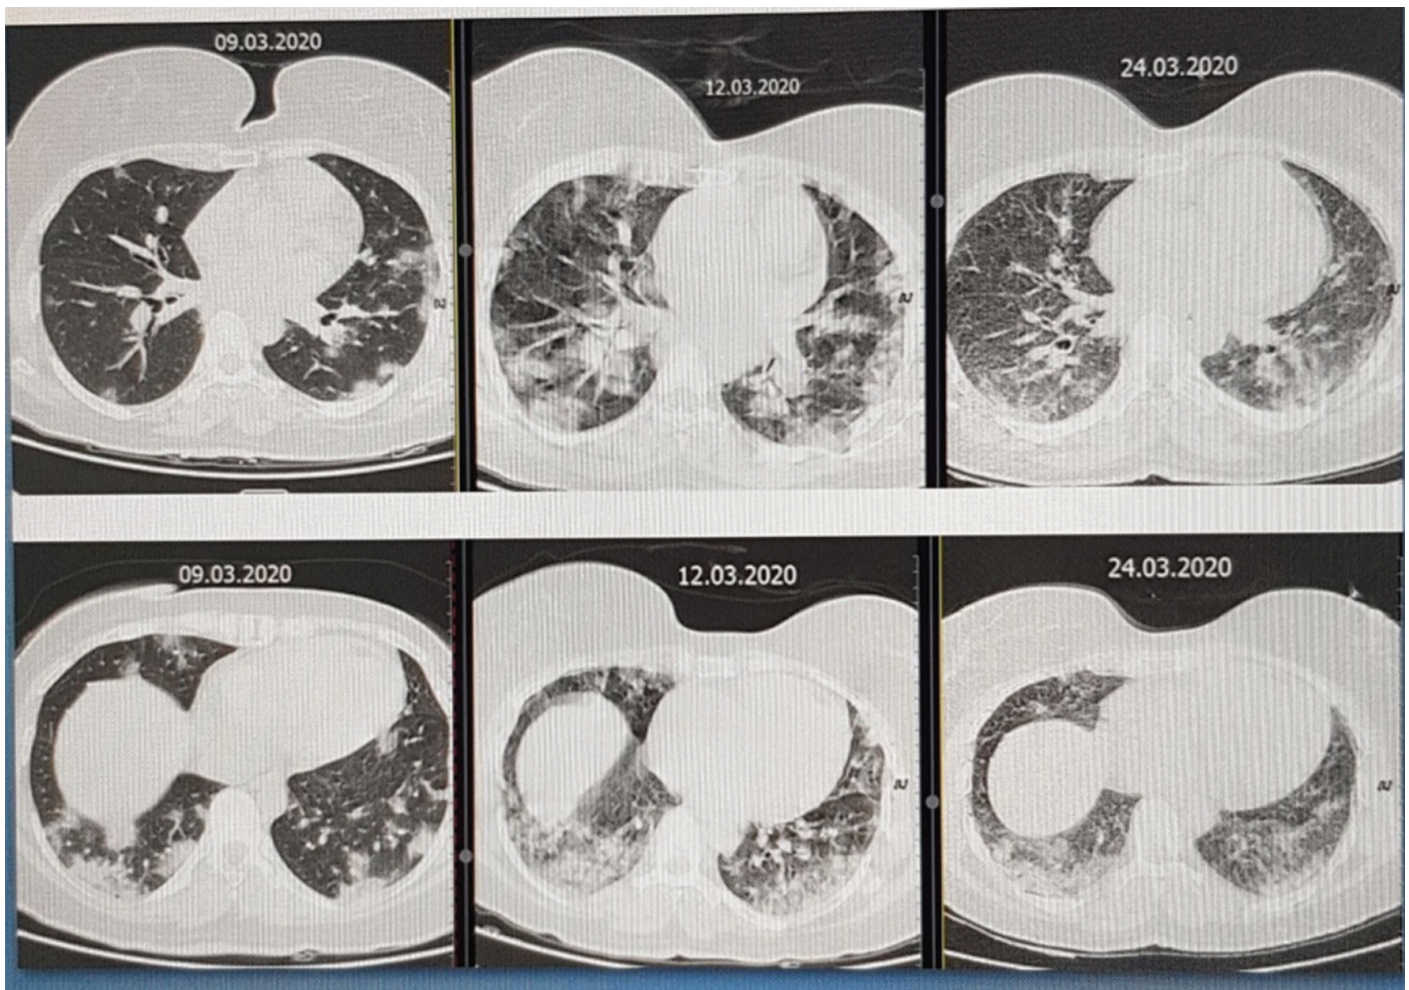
Appearance of pneumonic involvement in different axial sections in lung CT performed at three different dates during the disease process
